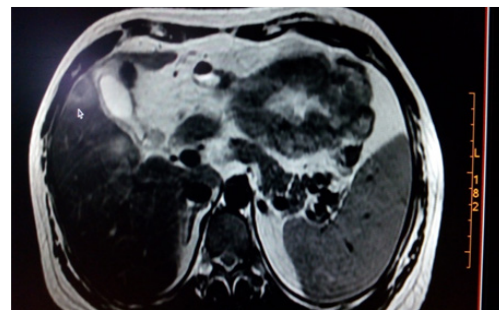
MRI showing a large lesion near gall bladder fundus.
